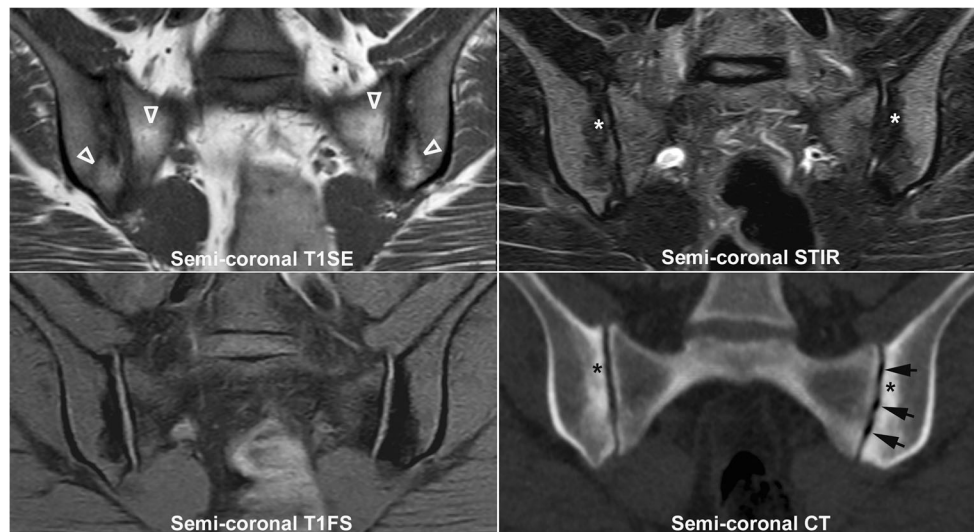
Nonspecific MRI lesions in conjunction with osteitis condensans ilii. A twenty-six-year-old woman with low back pain for 2–3 years irradiating to the right buttock and leg. The pain had both inflammatory and non-inflammatory characteristics being worst at night and improving by exercise. The pain aggravated after her first childbirth 18 months previously. She was suffering from morbid obesity with a BMI of 41 kg/m², which may be a confounder for the interpretation of elevated CRP levels [16]. CRP 18 mg/l (reference <8.0 mg/l), HLA-B27
